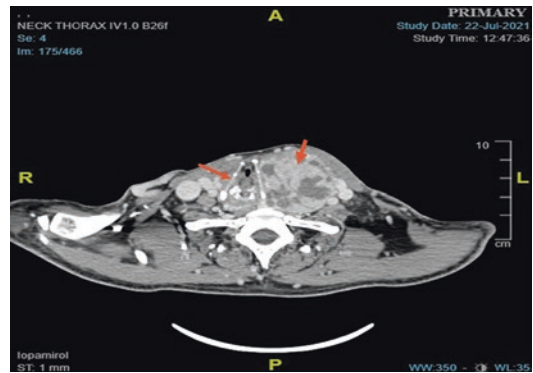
CT scan of the neck and thorax shows left thyroid lobe enlargement which is cystic and heterogenous (thick arrow). It is abutting the left thyroid cartilage (thin arrow) and causes airway displacement to the right side
